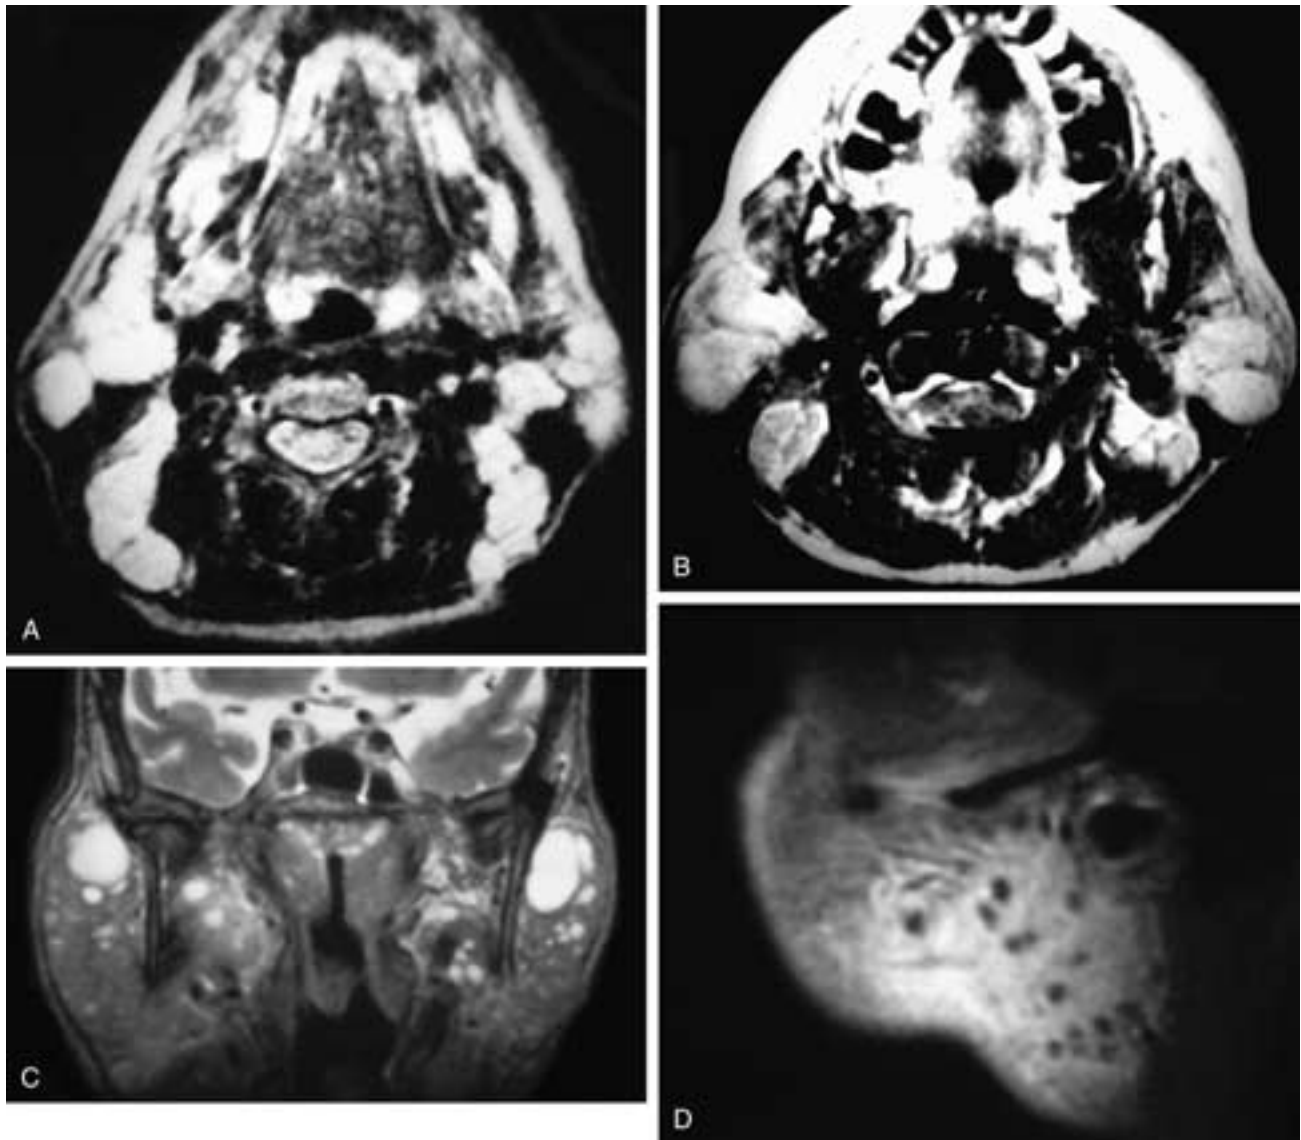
Axial T2-weighted MR images through the parotid glands (A) and more caudally in the neck (B) show multiple bilateral parotid masses and diffuse cervical adenopathy. This HIV-positive patient had lymphoepithelial cysts and cervical adenopathy. Coronal T2-weighted (C) and sagittal T1-weighted (D) MR images on another patient show multiple variably sized cysts in both parotid glands. In D note that the cysts are not uniformly distributed throughout the gland, as they are in SS (Fig. 39-61). This patient was HIV positive and had lymphoepithelial cysts.
